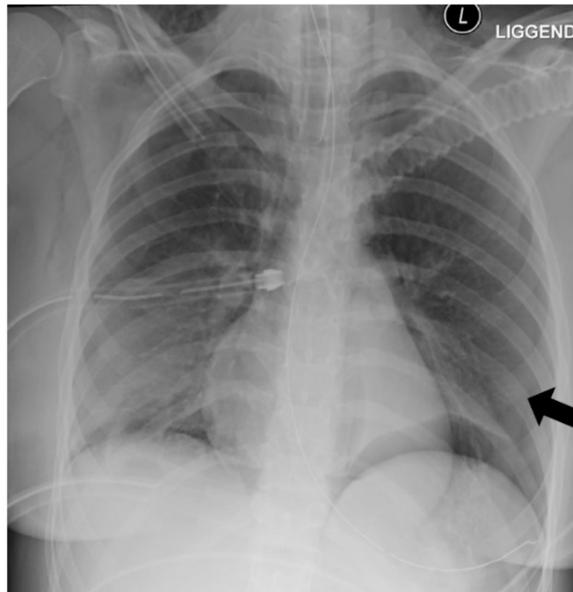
Chest X-ray 7 hours after extubation and 2 hours after reintubation (20:22 PM);new pneumothorax on the left side.
